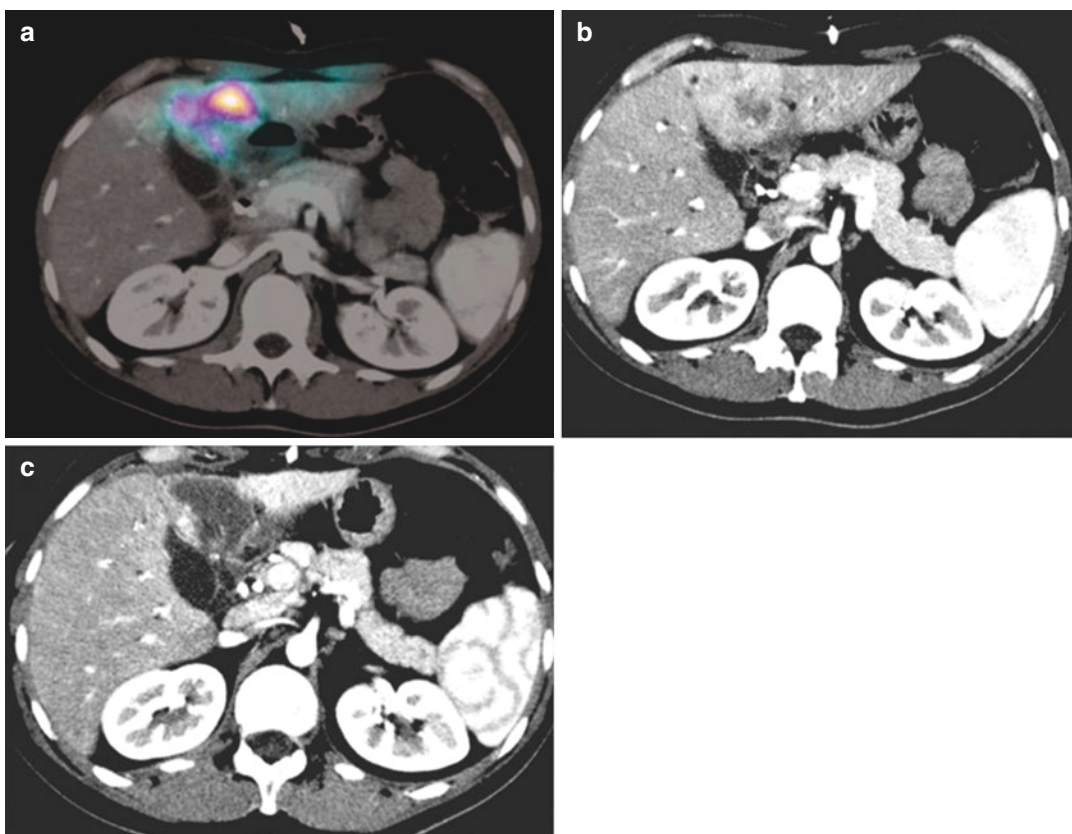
(a) $^{99\text{m}}\text{Tc}$ MAA SPECT/TC of liver lesion. (b) Pretherapeutic contrast-enhanced CT of liver lesion. (c) Contrast-enhanced CT of liver lesion 3 months post radioembolization showing excellent response
